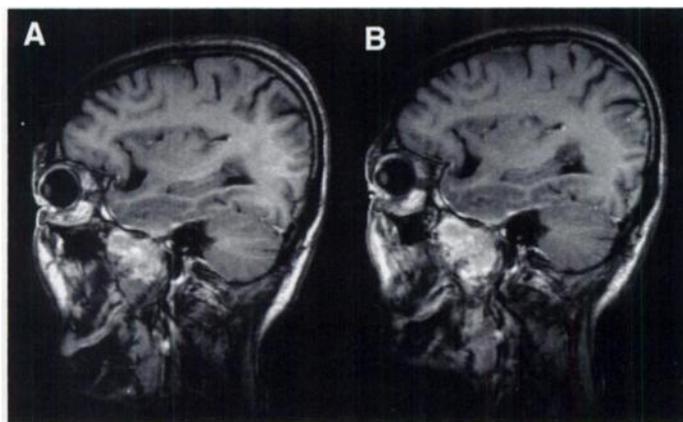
(A) Contrast-enhanced sagittal T1-weighted image (gradient-recalled echo [GRE], 450/9; flip angle, 90°) obtained before biopsy shows parapharyngeal meningioma extending from intracranial space. Tumor measured about $4 \times 2.8 \times 3.4$ cm. (B) Contrast-enhanced sagittal T1-weighted image (GRE, 450/9; flip angle, 90°) obtained after biopsy shows growth of parapharyngeal meningioma over 7 mo. Tumor measured about $4.6 \times 3.4 \times 3.4$ cm. Calculated doubling time of tumor was about 10 mo.
